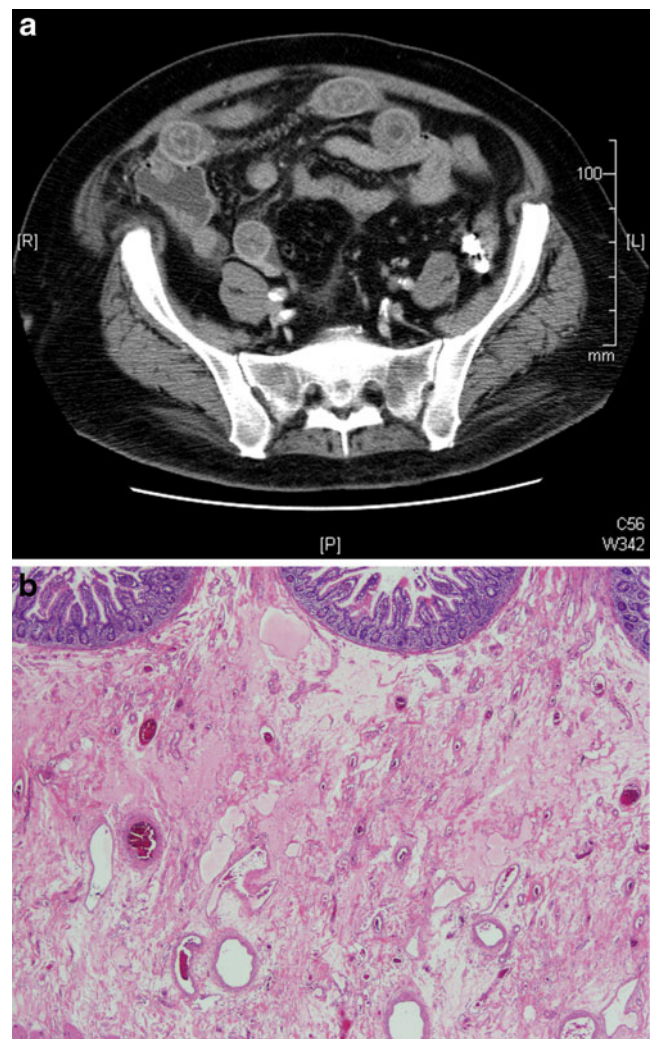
a CT scan of abdomen and pelvis with intravenous contrast shows several abnormal loops of small bowel with a target appearance indicating bowel wall edema. b A section of small bowel shows massive submucosal edema. There is no infiltration of the wall by lymphocytes
